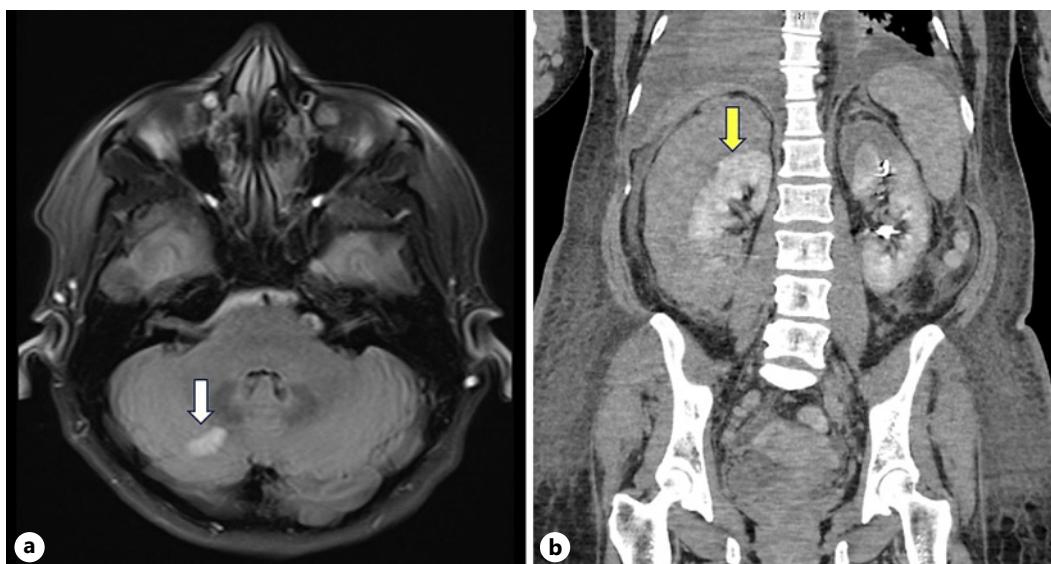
a Head magnetic resonance imaging with right cerebellar ischemic infarct T2 hyper intensity (white arrow). b Right perinephric hematoma on computerized tomography (yellow arrow).
